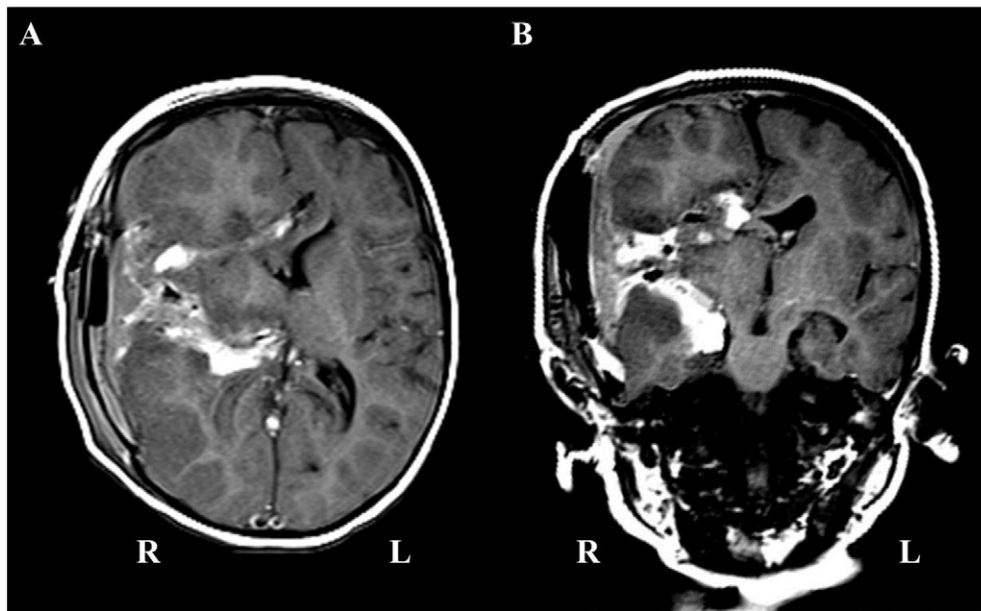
T1 axial (A) and coronal (B) MRI images show expected postoperative changes after peri-insular functional hemispherotomy with high T1 signals corresponding to the areas of right hemispheric disconnection.
